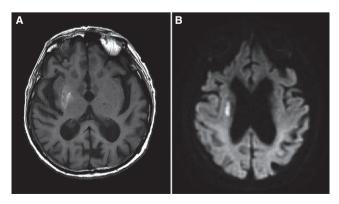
Brain magnetic resonance imaging revealing (A) T1-weighted hyperintensity of the right basal ganglia and (B) a diffusion-weighted hypersignal in the right centrum semiovale.
